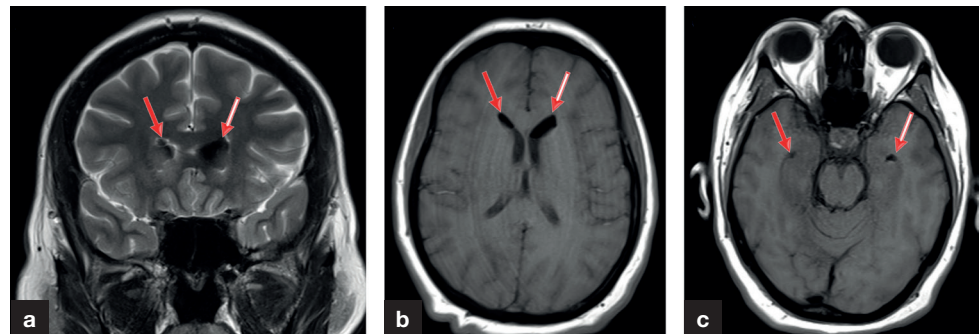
a. Coronal T2-weighted and (b, c) axial T1-weighted magnetic resonance images show air intensities (arrows) in the frontal and temporal horns of the bilateral lateral ventricle.
